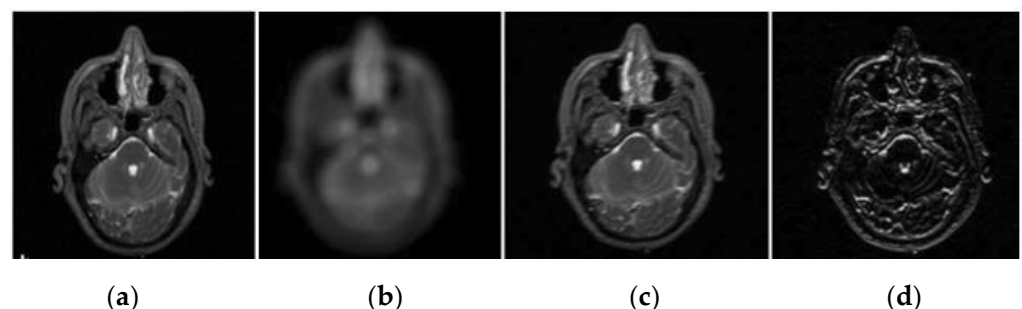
(a) Wavelet decomposition of MRI image, (b) input image, (c) lower frequency component, and (d) higher frequency component.
